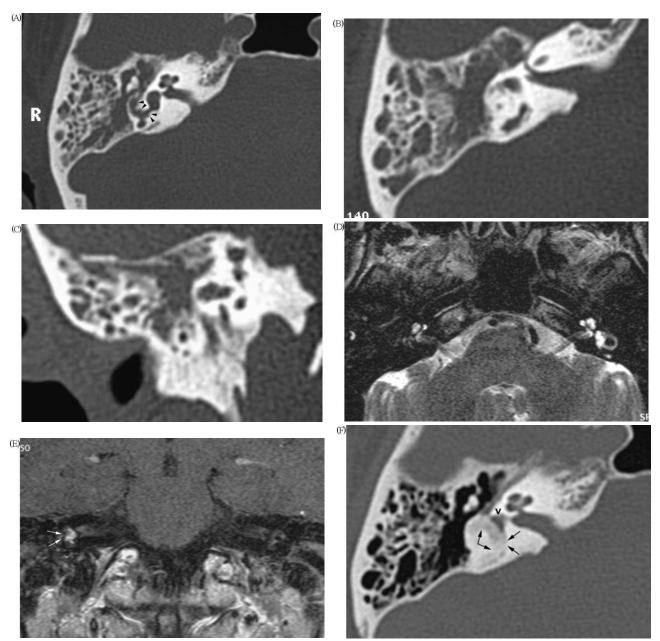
(A-F) COM, right anacusia and vertigo. Three months before, the patient had an acute external and middle ear otomastoiditis treated with antibiotics. (A) CT shows opacification of right middle ear and mastoid with irregular resorption of the bone adjacent to the lateral semicircular canal (arrowheads). Its walls appear unsharp, the diameter is abnormally enlarged (A-C). Six months later MR demonstrates the abscence of the normal hyperintense signal on T2 (D) combined with enhancement (E) of the vestibule and semicircular canals on T1 (arrows). A CT examination performed in the same period (F) demonstrates marked enlargement of the semicircular canals, replaced by mineralized content (arrows): labyrinthine ossification. Part of the vestibule is still detectable (V).
